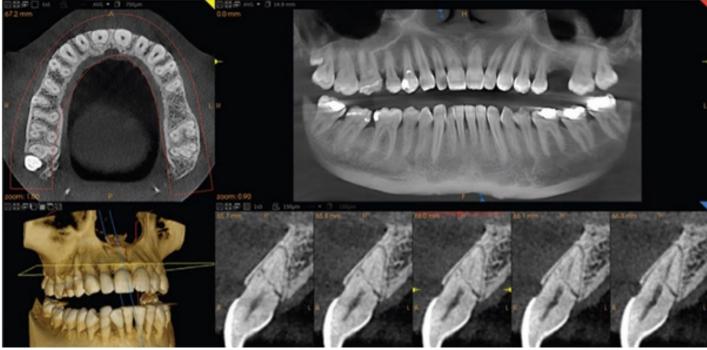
CBCT in orthodontics
